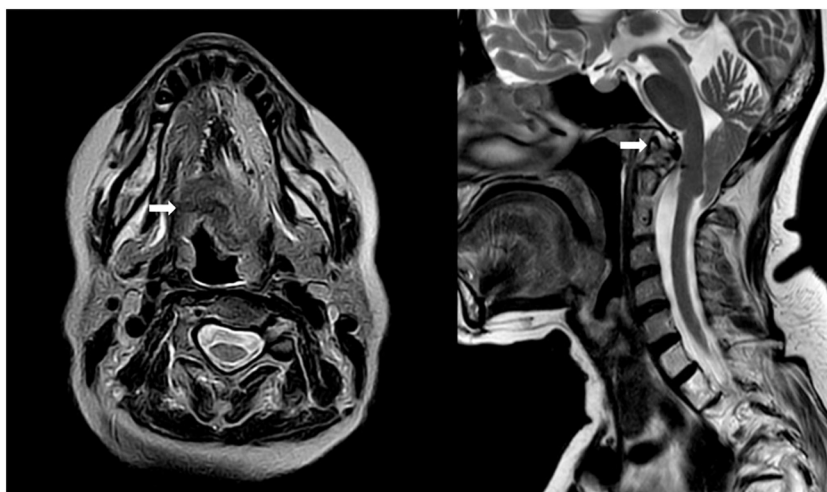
MRI of tongue and cervical.
